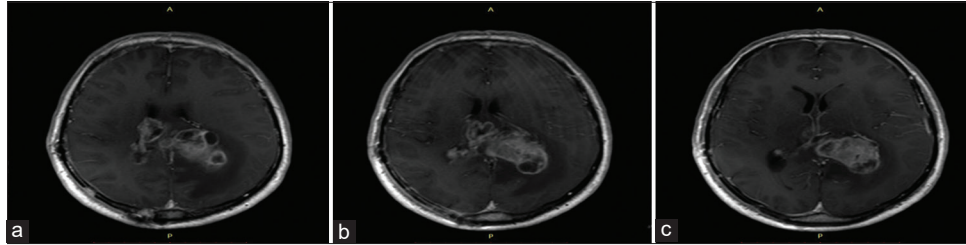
Postoperative MRI one month after surgery. (a-c) Axial T1WI Gd MRI showing notorious residual lesion growth.
